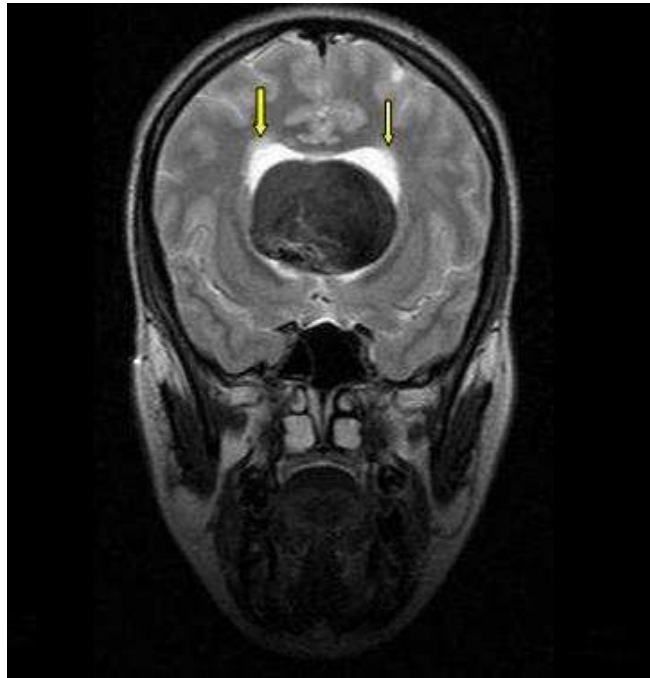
Coronal T2 weighted spin-echo (SE) magnetic resonance imaging (MRI) of a 22-year-old woman with intrinsic third ventricular craniopharyngioma. The MRI of brain (Philips intra 1.5 T, TE:100 msec, TR: 3641.6 msec) at the level of temporal lobes revealed large midline hypointense mass in third ventricle with dilatation of lateral ventricles and subtle hyperintensity around lateral ventricle due to hydrocephalus (arrow).
